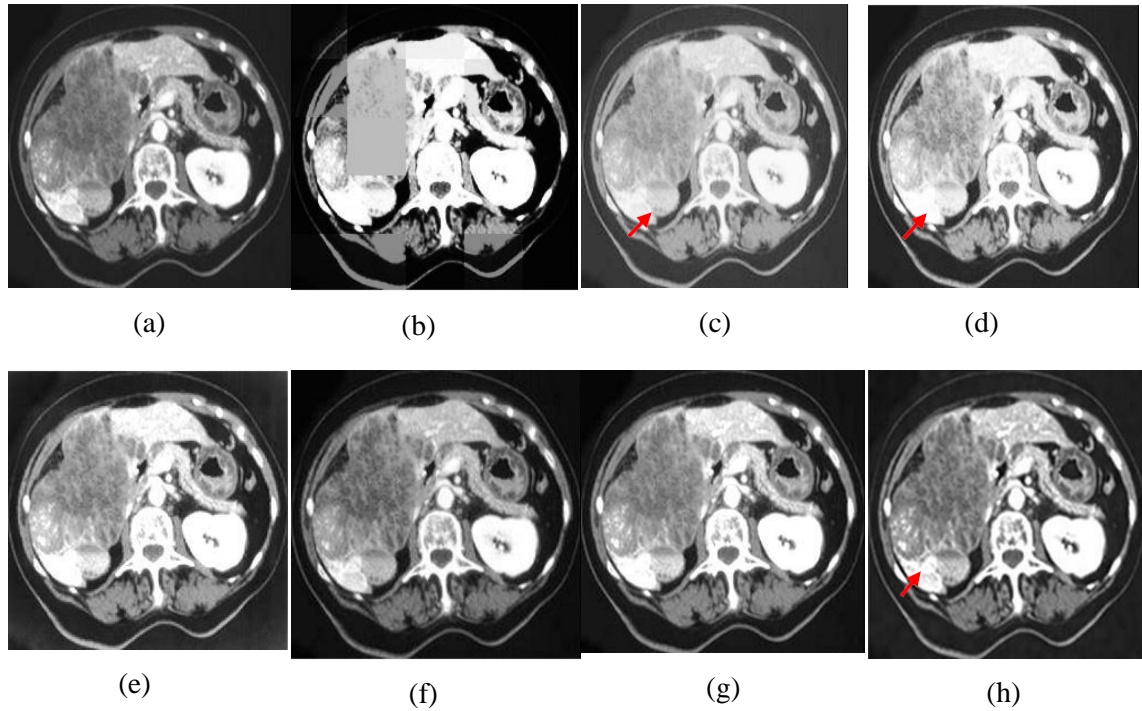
Experiment outcomes of the 'CT-1' Image (a) Original image, (b) S-curve, (c) AGC-DWT, (d) AGC WHD, (e) GAGC-DWT, (f) EBCHE, (g) TCHE-DWT, (h) Proposed scheme
